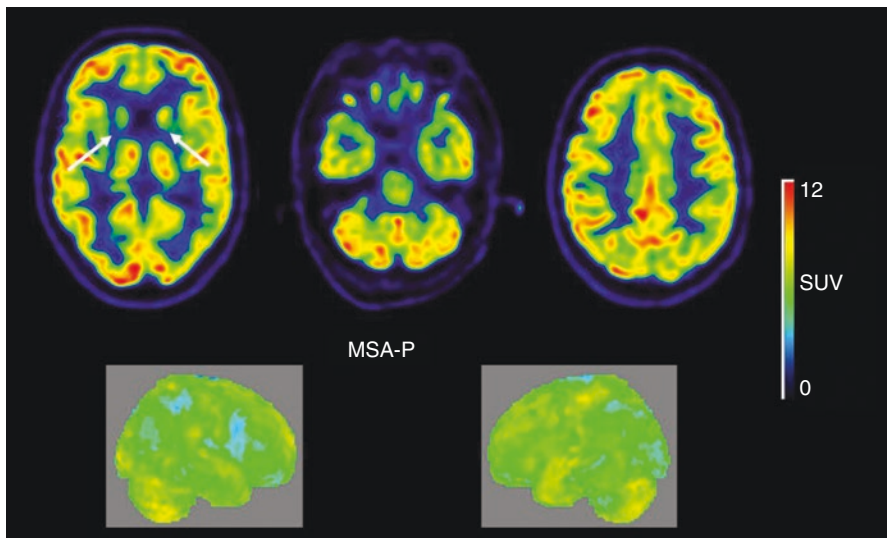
FDG-PET images from a representative case of MSA-P, showing decreased metabolism in the putamen bilaterally (arrows). Courtesy of Dr. Irina Savitcheva, Department of Nuclear Medicine, Karolinska Huddinge University Hospital
